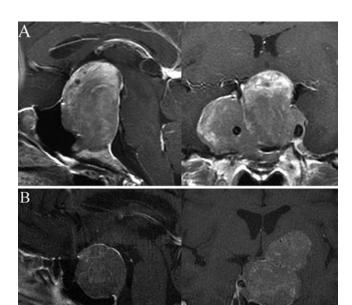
A and B: Sagittal and coronal contrast-enhanced MR images of WHO atypical null-cell macroadenomas, with invasion of multiple compartments.
